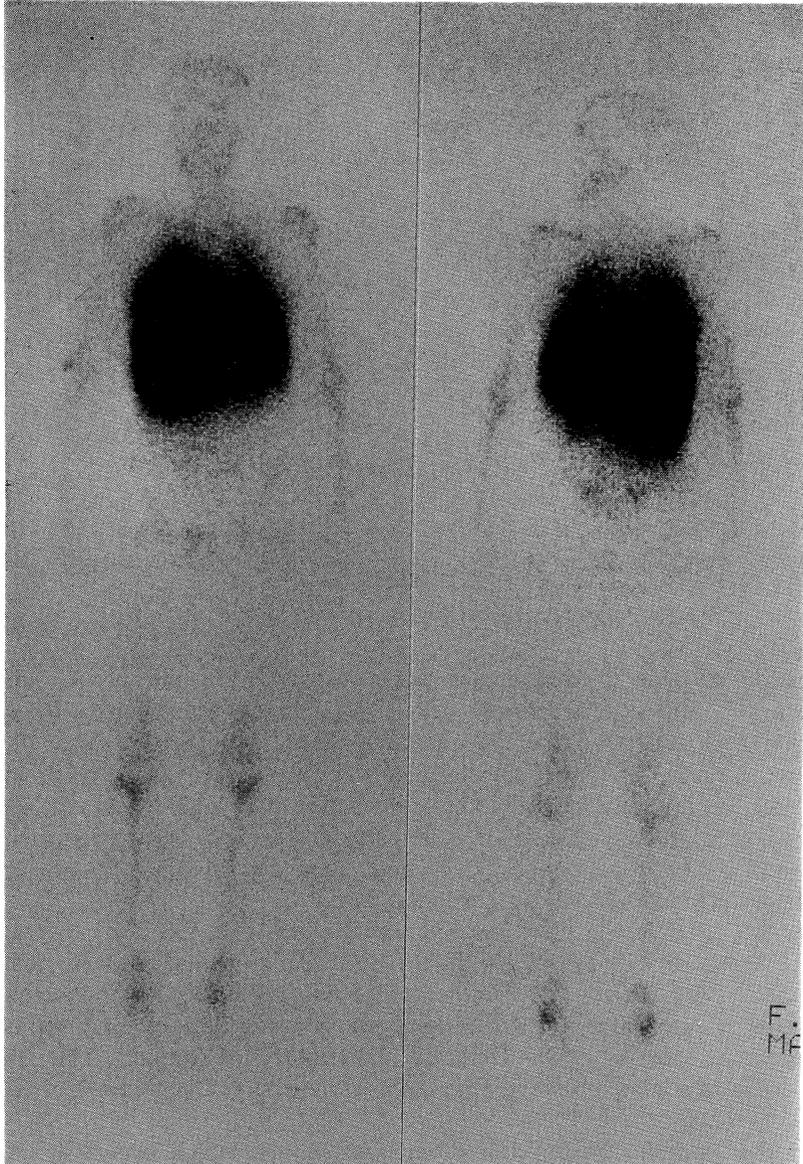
Bone-marrow scintigraphy with  $^{99m}\text{Tc}$ -sulfur colloid showed poor accumulation in lumbar and pelvic marrow. However, peripheral expansion of reticuloendothelial marrow is noted in distal femur and proximal tibia.
